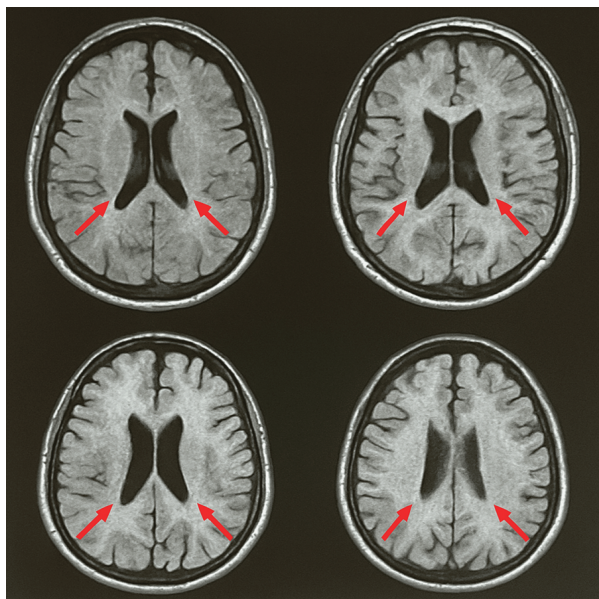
Axial Brain MRI – FLAIR and DWI Sequences.
